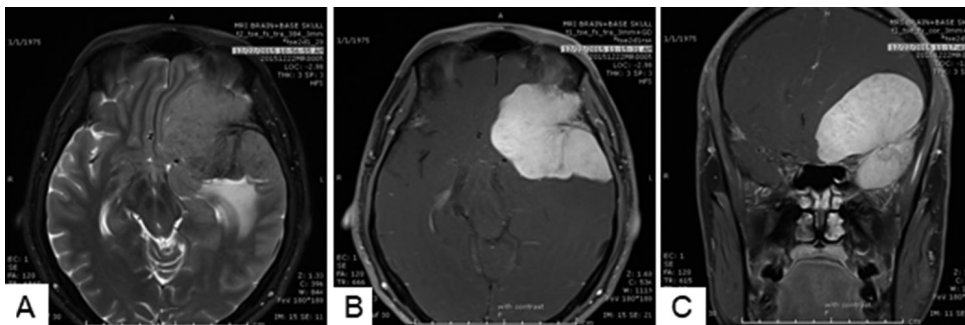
Axial fat suppression T2-weighted image (A) and axial (B), coronal (C) Gd-enhanced fat suppression T1-weighted image demonstrated a meningeal-based mass at left anterior and middle cranial fossa which appeared isointensity on T2WI with homogeneous enhancement.
